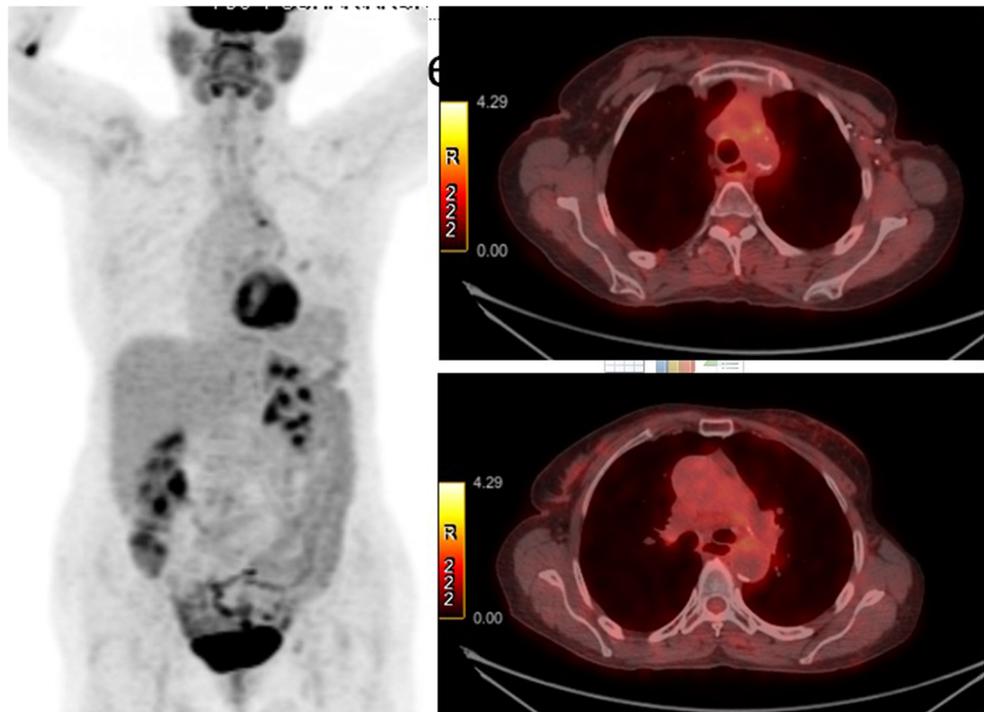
Post-therapy FDG PET/CT showing complete metabolic response in the upper thoracic esophagus, left internal mammary nodes, and left mediastinal nodes
